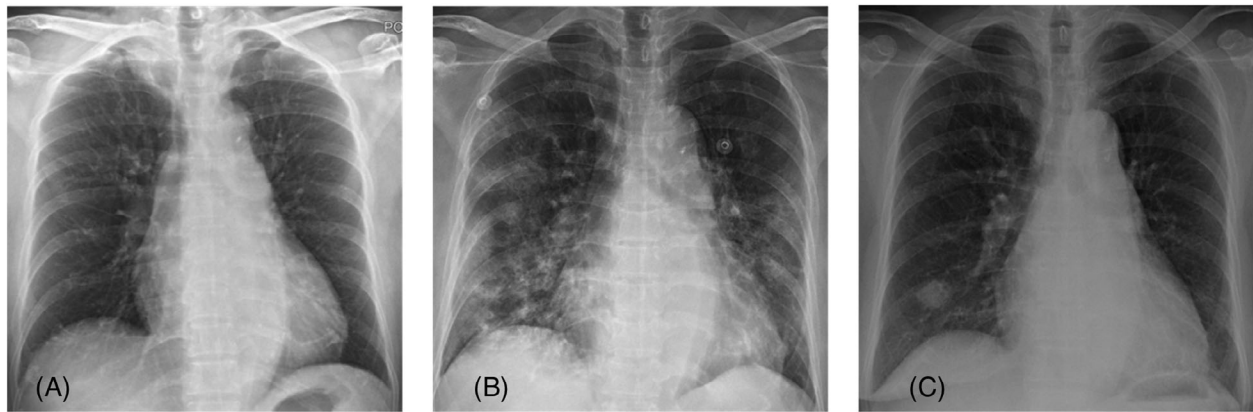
(A) On the first day of admission, initial chest radiography was performed without infiltration. (B) On the seventh day of admission, chest radiography showed bilateral alveolar infiltration, predominant at the lower and peripheral area. (C) Round circumscribed lung nodule at right lower lung area with minimal reticulation in both lungs 12 weeks after Covid-19 was detected.
